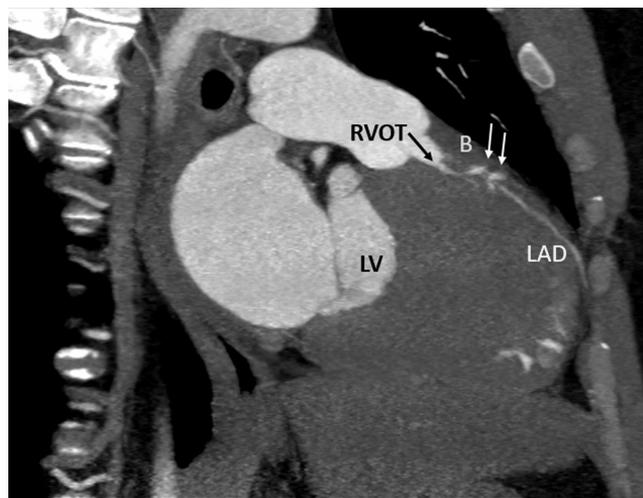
CT image showing RV crypts present in the soft tissue of the myocardial bridge compressing the LAD.
